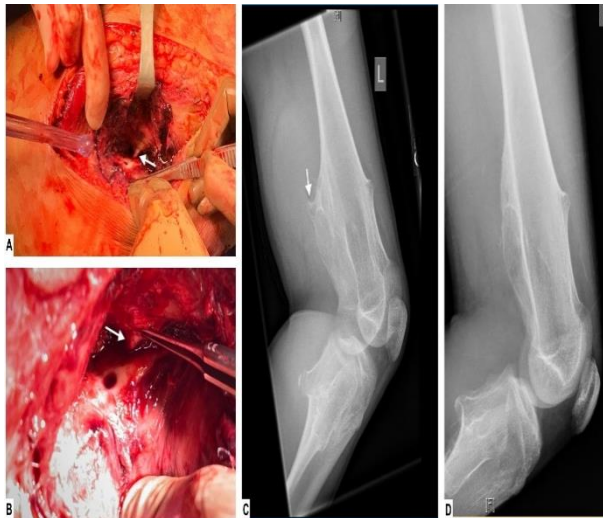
(A & B) Intraoperative Pictures demonstrating a sharp tipped osteochondroma (arrow) aligning with an anterior traumatic arteriotomy of the left SFA (arrow). (C & D) Preoperative and postoperative comparative plain films following partial resection of the posterior femoral osteochondroma (arrow).
